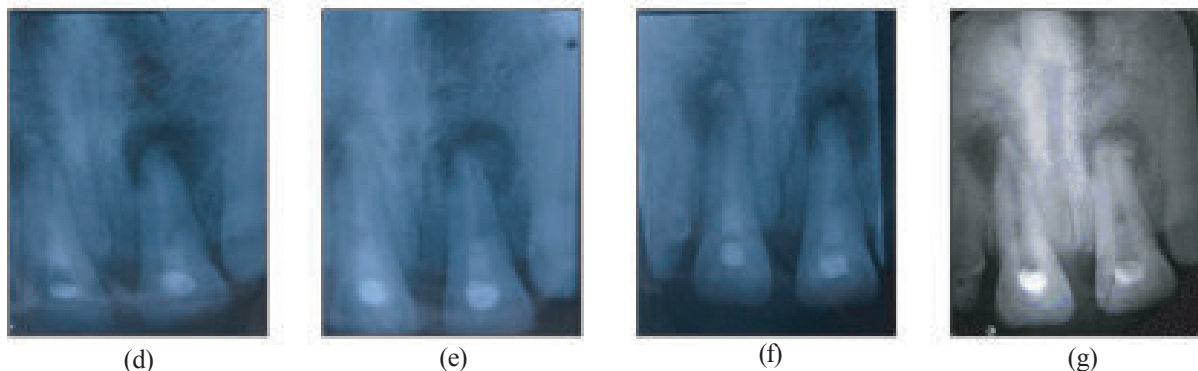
Follow up radiographic view of that teeth, just after application of $\text{Ca}(\text{OH})_2$ (d), at 3 months interval (e), at 6 months interval (f), & at 8 months interval (g).
